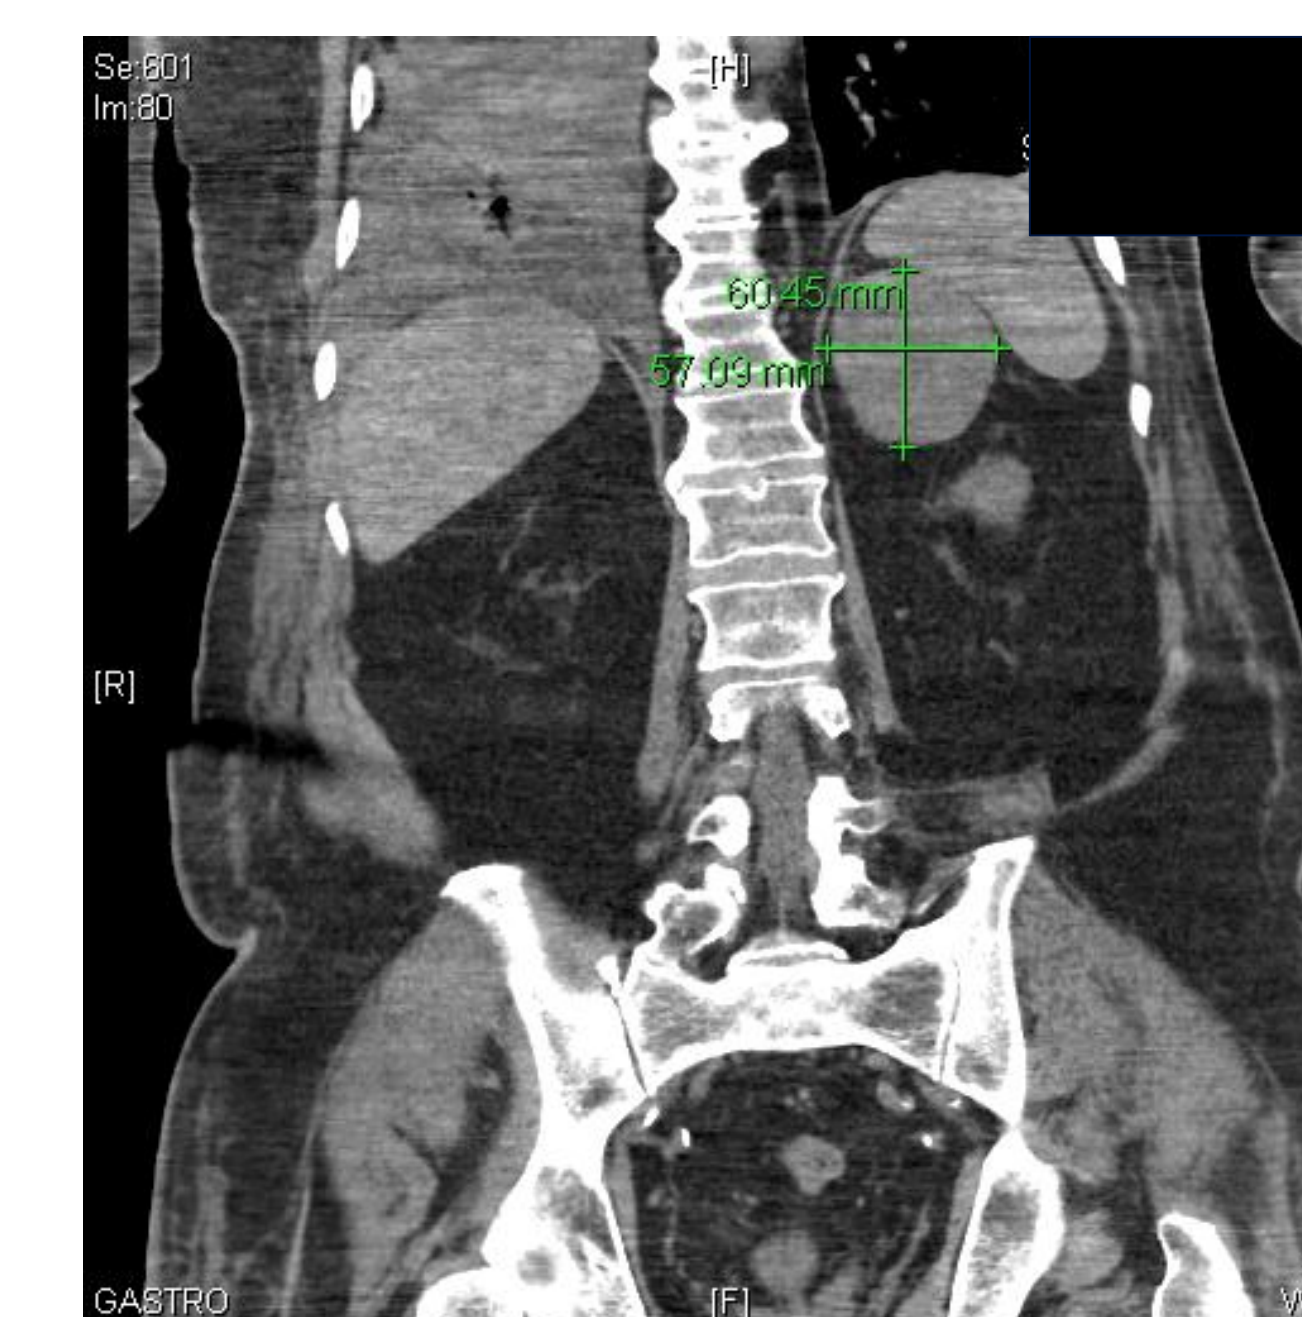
Coronal view of the adrenal mass during a CT-guided adrenal biopsy
